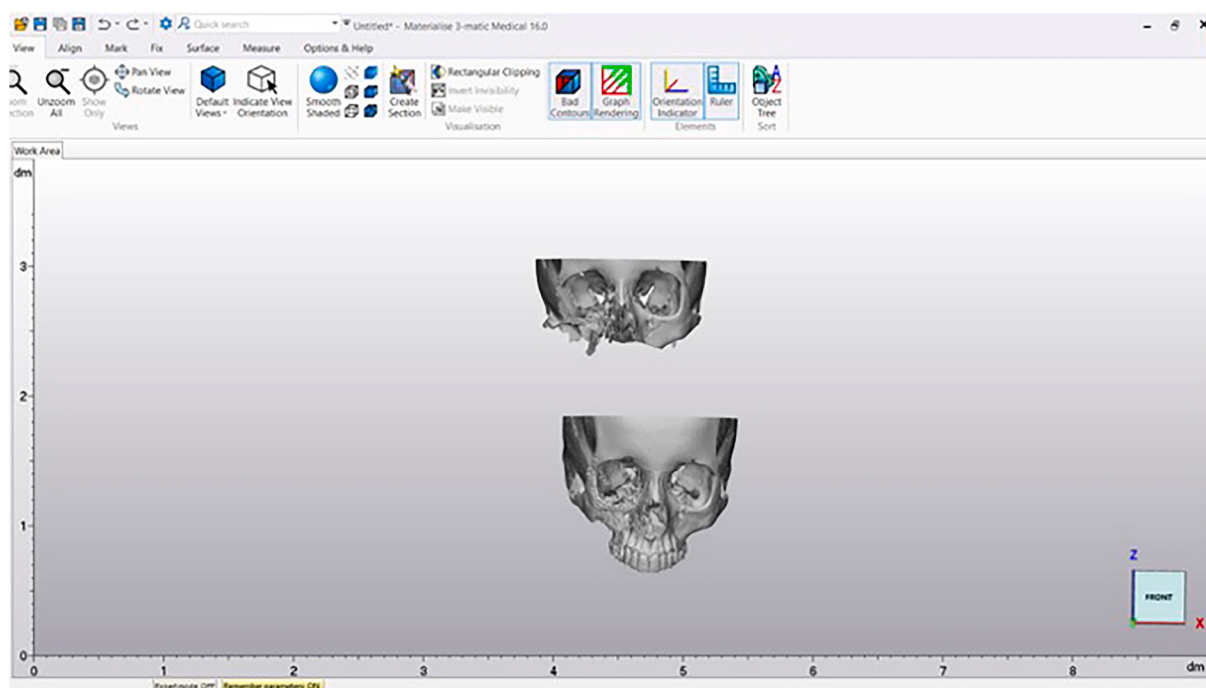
Importing anatomical models to 3-Matic Medical from CBCT of the same patient.
